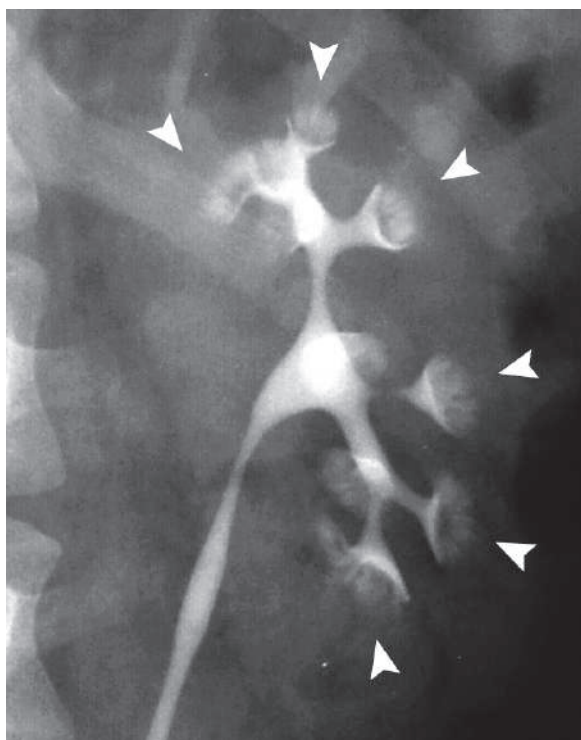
Intravenous urography radiograph of a patient with sponge kidney shows the classical collecting duct paintbrush appearance (*arrowheads*)
